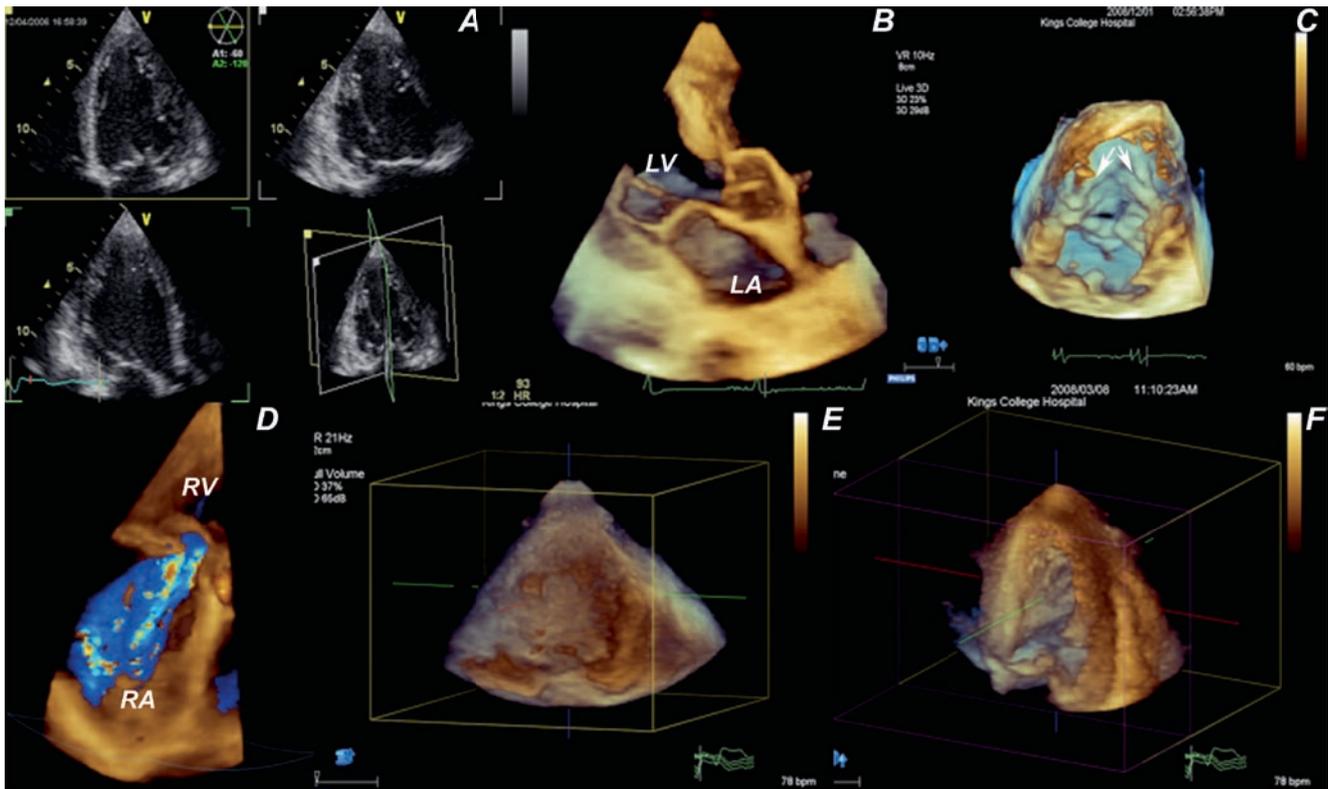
(a–e) Examples of the possible modes available using 3DE. (a) Triplane view showing three apical views (4 chamber, 2 chamber, and 3 chamber), (b) parasternal long axis using live 3D mode. (c) 3D zoom showing the left ventricular aspect of the mitral valve (arrows = chords). A ruptured chord can also be seen attached to the anterior
